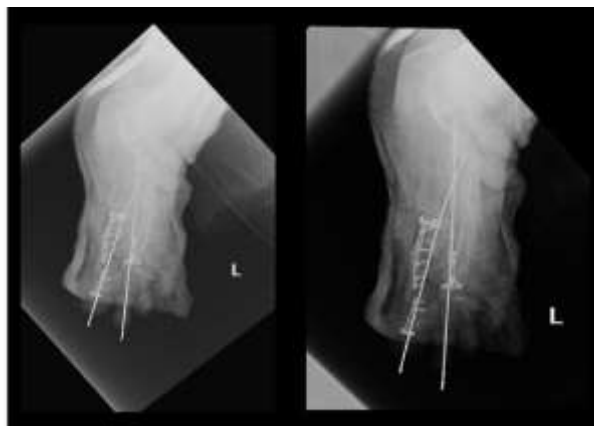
Post-op AP/Oblique Radiograph of the left foot
